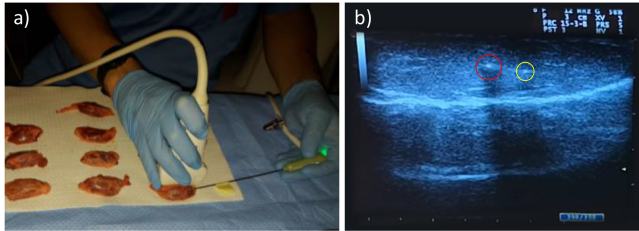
Photo during the guided insertion of the MW probe inside one of the thyroid samples (a) and an ultrasound image of the tissue transversal section containing the MW antenna and the array A_2 (b). The red and yellow circles in (b) contain the transversal sections of the antenna and A_2 , respectively.
